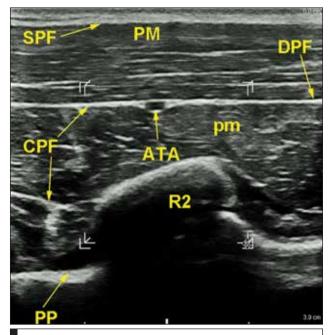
Ultrasound image of the anterior thoracic wall shows the pectoralis major muscle (PMM), pectoralis minor muscle (pmm), superficial pectoral fascia (SPF), acromiothoracic artery (ATA), clavipectoral fascia (CPF), parietal plaeura (PP), lateral pectoral nerve, intercostal muscle (ICM) and ribs (R)
